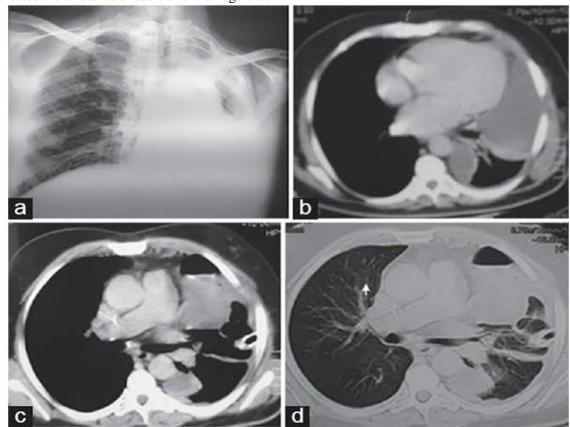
Left side encysted pleural effusion before and after intercostal tube, which was inserted under CT-guidance
